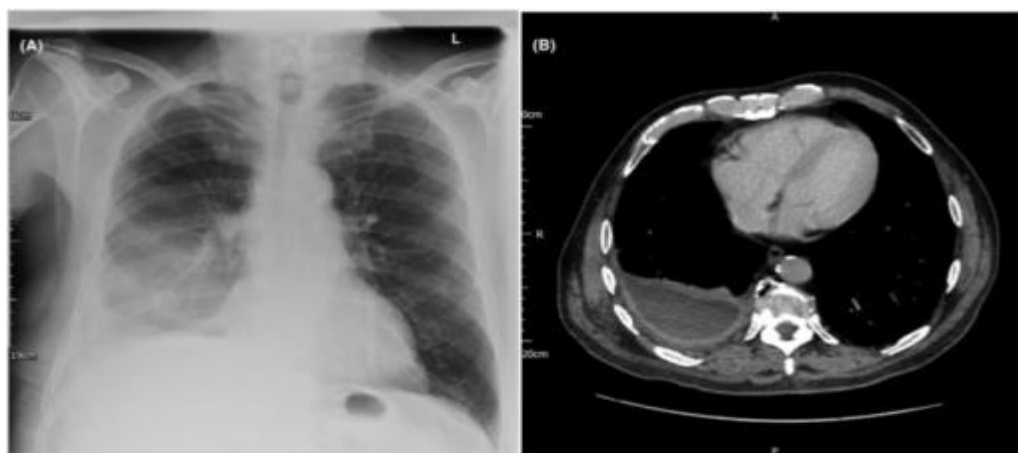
(A) Chest X-ray shows a rounded opacity that does not obscure the heart borders or the diaphragm. (B) Chest CT reveals posteriorly loculated pleural collection. Note the enhancing pleura (split pleura sign) and the extra pleural fat hypertrophy (6)
